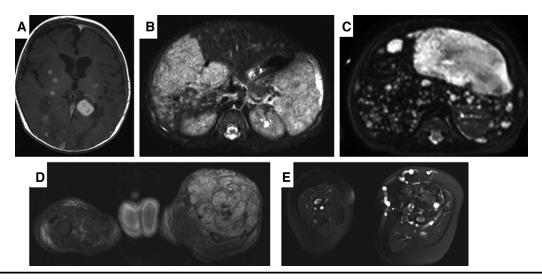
A, Cerebral pyogenic granulomas. Axial contrast-enhanced T1-weighted images at 3 months of age demonstrating multiple solid enhancing cerebral lesions. B, Liver and spleen pyogenic granulomas. Contrast-enhanced fat-saturated axial T1-weighted image at 1 month of age demonstrating extensive involvement of right hepatic lobe and spleen. C, Axial fat-saturated T2-weighted image at the age of 2.5 months demonstrating a large cystic lesion in the left liver lobe with numerous smaller lesions throughout the liver and spleen. D, Musculoskeletal pyogenic granulomas. Axial fat-saturated T2-weighted images at birth showing a large, well-defined, lobulated, hypervascular intramuscular mass in the left thigh. E, Marked shrinkage of the pyogenic granuloma with residual dilated veins at 1 year of age.
